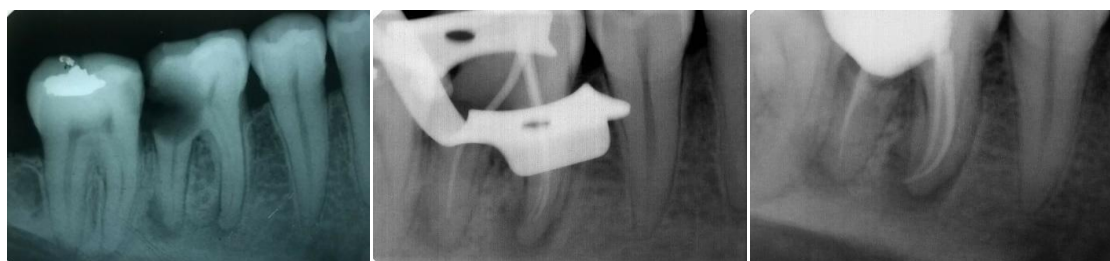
Pre operative radiograph Figure 2: Master cone radiograph Figure 3: Post obturation radiograph
